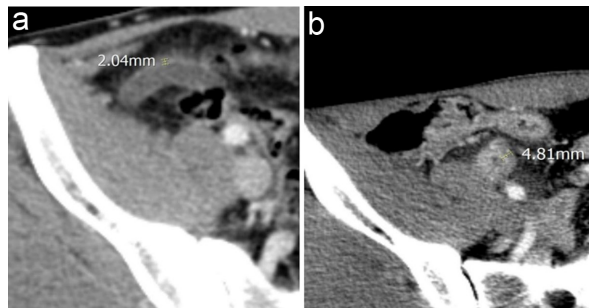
Example of the wall thickness of the appendix. On contrast-enhanced abdominal CT scans, it was graded as 0 while the wall thickness of the appendix was below 3 mm (a) and 1 if 3 mm or above (b).
